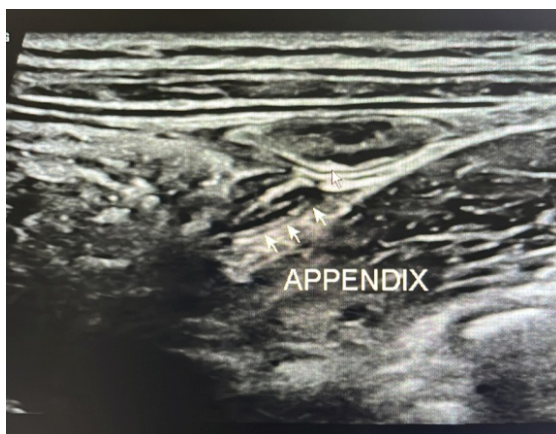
Ultrasonographic features of a normal appendix (arrow)
